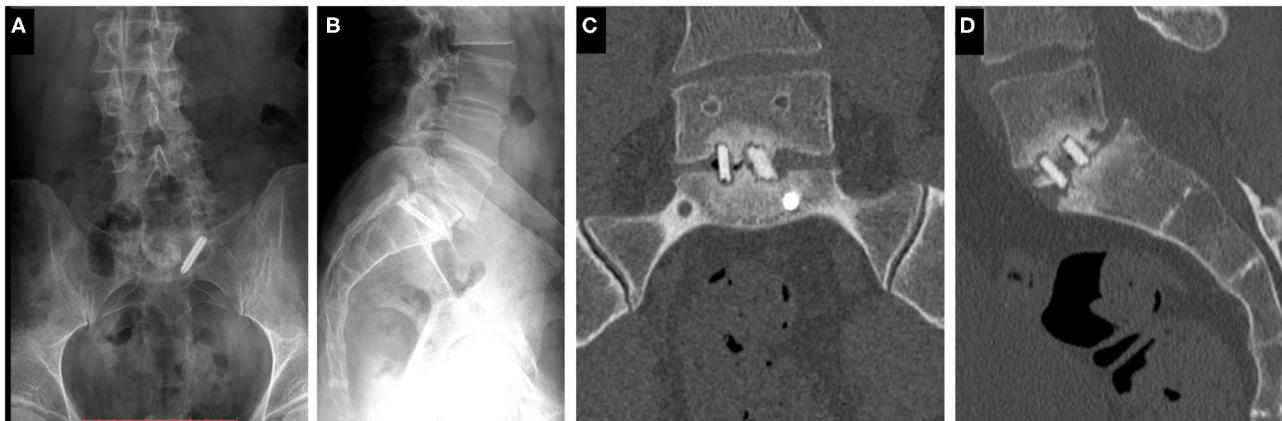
Clinical case of a 38-years-old male patient suffering from low back pain. The patient previously underwent multiple surgeries at the L5–S1 level. A broken left sacral screw can be identified on the standing X-ray images of the patient (A, Coronal, B, Sagittal plane). Signs of non-union are identifiable in the intervertebral space on the CT scan images of the L5 vertebra and the sacrum (C, Coronal, D, Sagittal plane).
